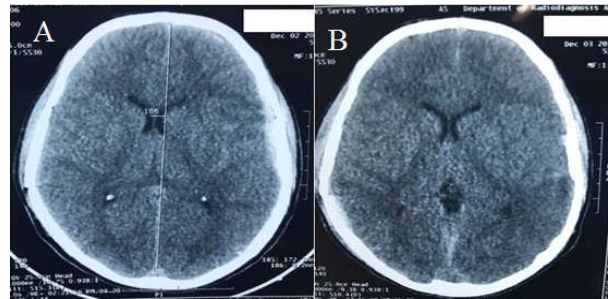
Case no. 4 (A) initial CT head showing left acute SDH and associated left temporal contusion & right temporal bone fracture, (B) repeat CT head having spontaneous resolution of SDH
